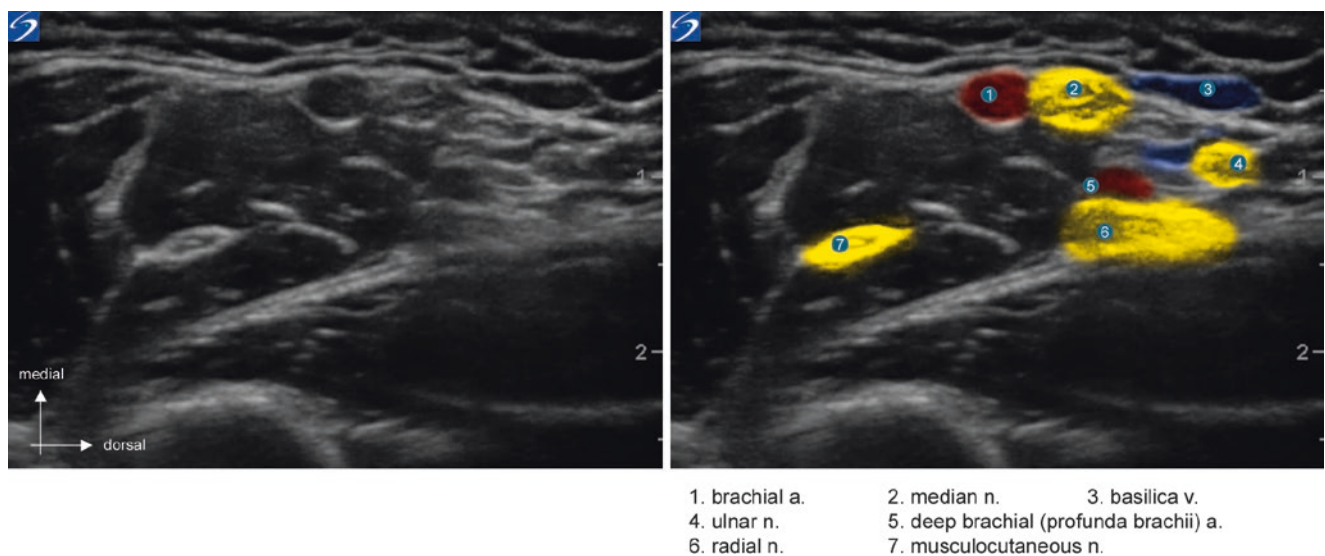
“Axillary” transverse ultrasound section showing median nerve dorsal to the brachial artery
